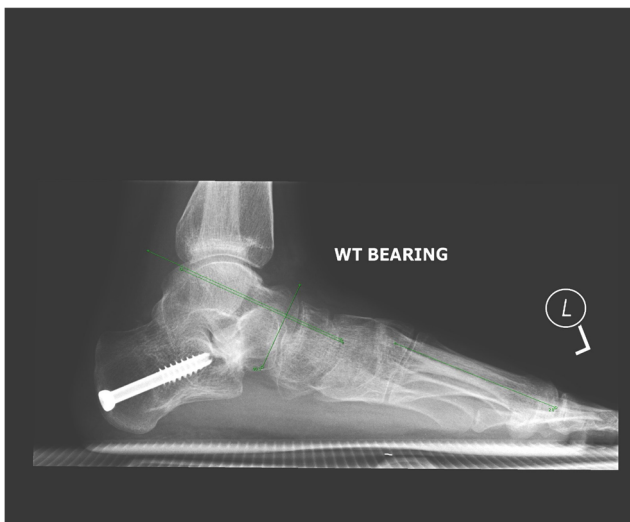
Patient A10 post correction weight-bearing lateral foot X-ray showing Meary's angle of -2.8°
